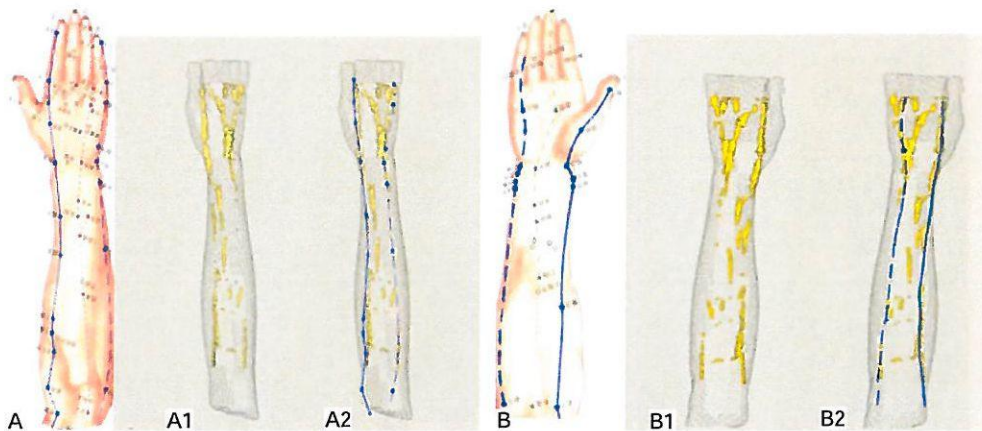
Based on MRI images of upper limbs, the constructed connective tissue strings (A1, B1) are compared with blue Large Intestine meridian of Hand-yangming (A, A2) and Lung meridian of Hand-taiyin (B, B2). The constructed connective tissue strings are rendered yellow and the traditional meridians are shown in blue.
